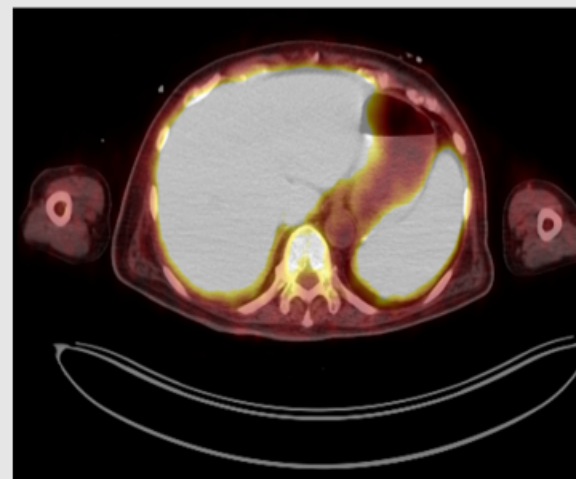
PET CT showing increased uptake in spleen, liver and marrow
